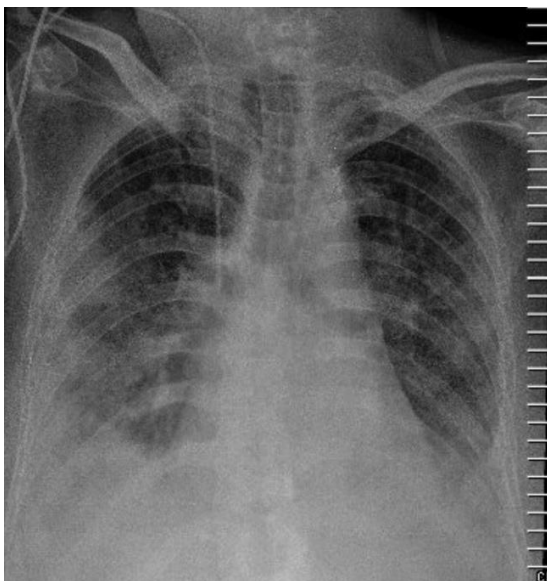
Chest X-Ray (11th Day)
